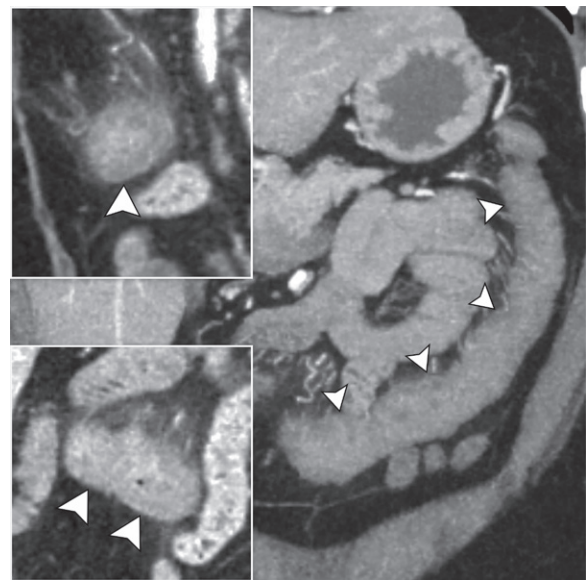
Colonic ischemia in a 48-year-old woman with factor V Leiden thrombophilia who presented with hematochezia. Coronal arterial phase maximum intensity projection (main image), sagittal arterial phase (top inset), and coronal portal venous phase (bottom inset) CT images show circumferential transverse colonic wall thickening with pericolonic fat stranding (arrowheads in all images). Figure E7 is an endoscopic image in this patient that shows diffuse colonic inflammation characterized by erosions, erythema, friability, and granularity. Tissue samples taken during colonoscopy showed ulcerated colonic mucosa, with fibrosis of the lamina propria, which are consistent with ischemic injury.
